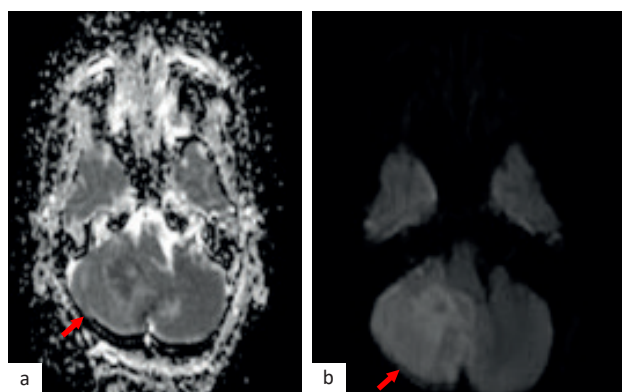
ADC and DWI of patients. (a) A signal on ADC (red arrow); (b) DWI showed slightly restricted diffusion (red arrow). ADC=apparent diffusion coefficient; DWI=diffusion-weighted imaging
